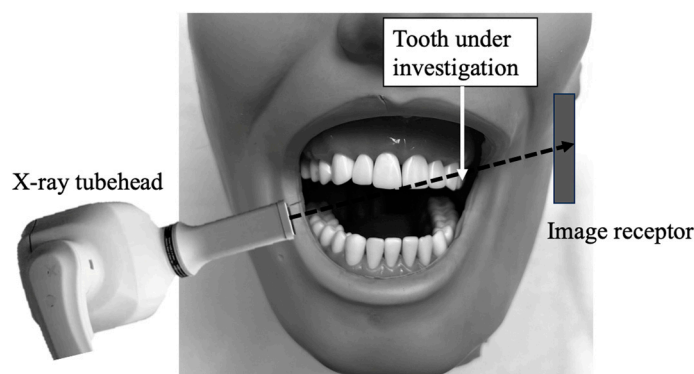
Set-up for extraoral periapical radiography (EOPA).
